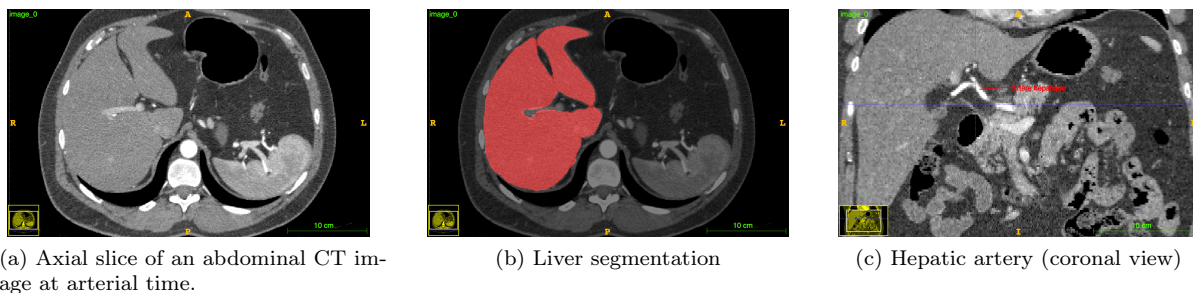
3D CT image of an abdomen (arterial time).
